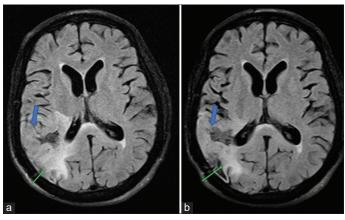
(a) Pre-treatment axial fluid-attenuated inversion recovery (FLAIR) image showing perilesional edema (green arrow); (b) Post-treatment (day 20) axial FLAIR image showing reduction in the perilesional edema (green arrow) and regression in the right ventricular compression
